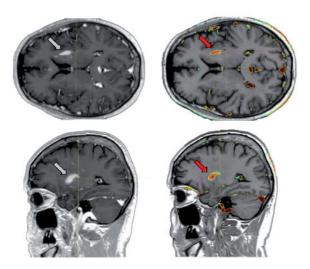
Comparison of Gd contrast MRI images (left) and images enhanced by described method (right). Stroke lesion visible on contrast images (marked by an arrow) was precisely identified and highlighted by our software.
